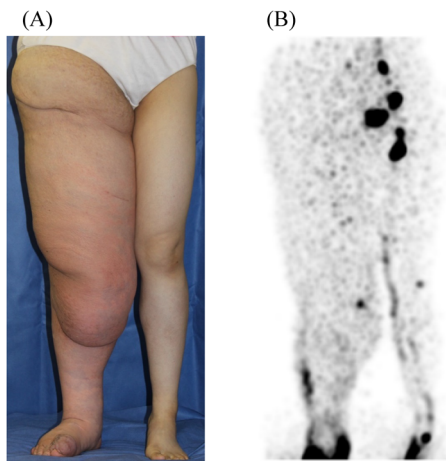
(A) Frontal view of the lower limbs. (B) Radionuclide lymphoscintigraphy. Increased radiotracer accumulation in the right calf and no lymph nodes at the right groin.
